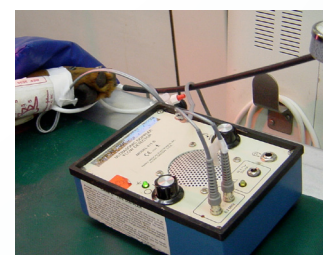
Arterial blood pressure measured indirectly with Doppler
